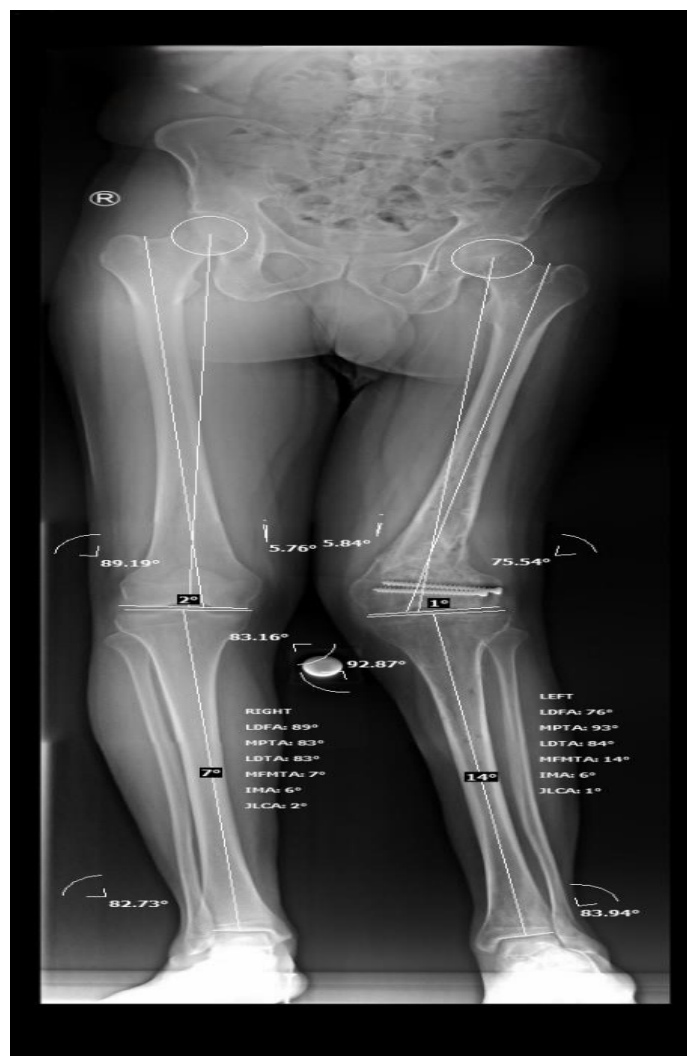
3-Joint Alignment view radiography shows LDFA=76°, MPTA=93°, MFMTA=14°. LDFA=lateral distal femoral angle, MPTA=medial proximal tibia angle, LDFA=lateral distal femoral angle, MFMTA= mechanical femoral mechanical tibia angle, IMA=inter mechanical anatomical angle, JLCA=joint line convergence angle
